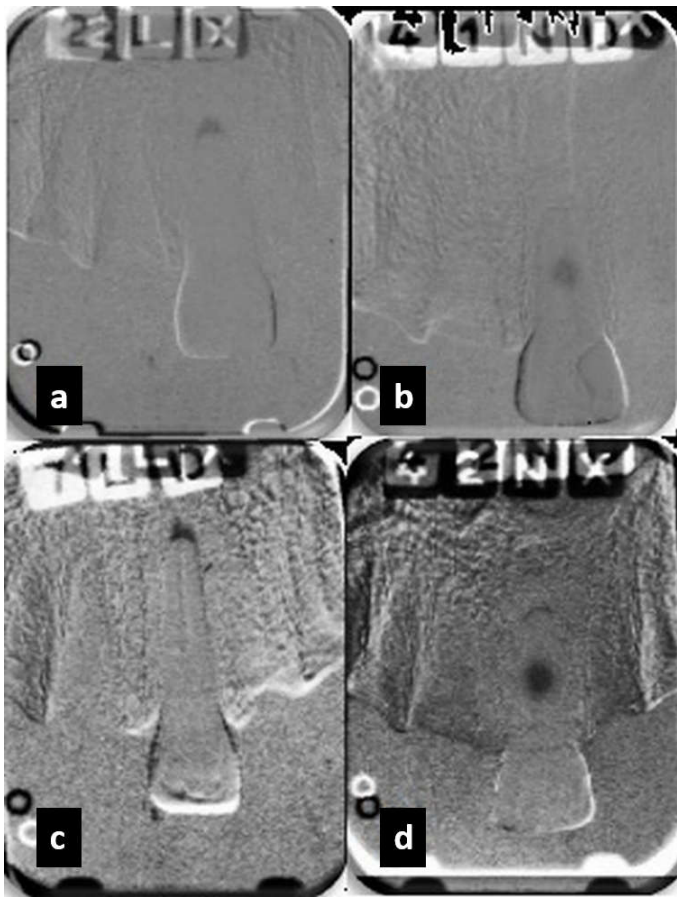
Digital linear subtraction radiography with apical (a) and vestibular (b) resorption. Digital logarithmic subtraction radiography with apical (c) and vestibular (d) resorption
